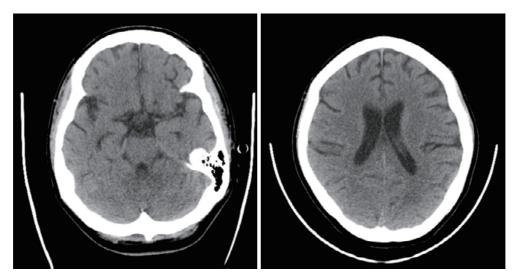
Computed tomography (CT) of the brain showed neither profound intracranial hemorrhage nor vessel infarction
